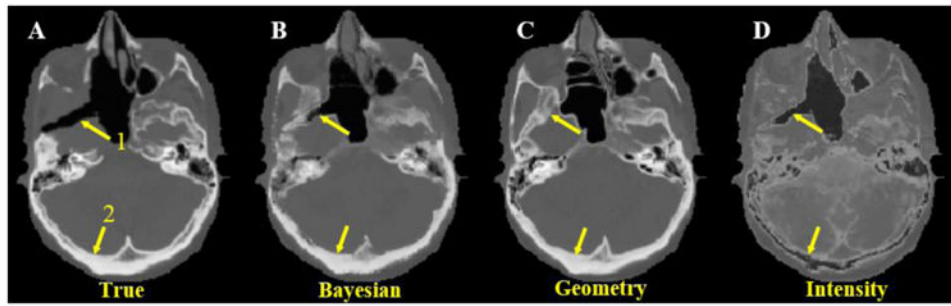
Axial view of true CT scan (A) and synthetic CT's by Bayesian (B), geometry (C) and intensity (D) approaches. Arrow 1 indicates an air region where the geometry approach erroneously detects bone. Arrow 2 indicates bony anatomy where the intensity approach detects air instead. In both regions, the proposed Bayesian approach correctly identifies the true electron density.
